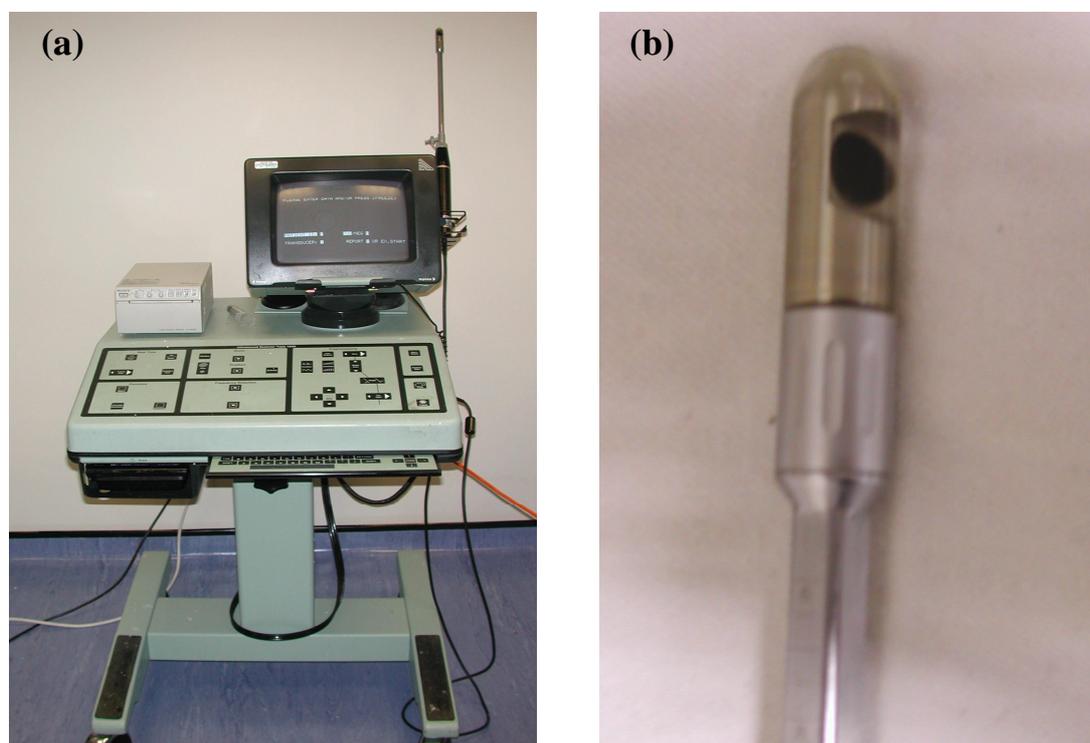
a) Ultrasound machine (model 184610) with b) 10 MHz transrectal mechanically rotating endoprobe, with plastic cone filled with distilled water.
